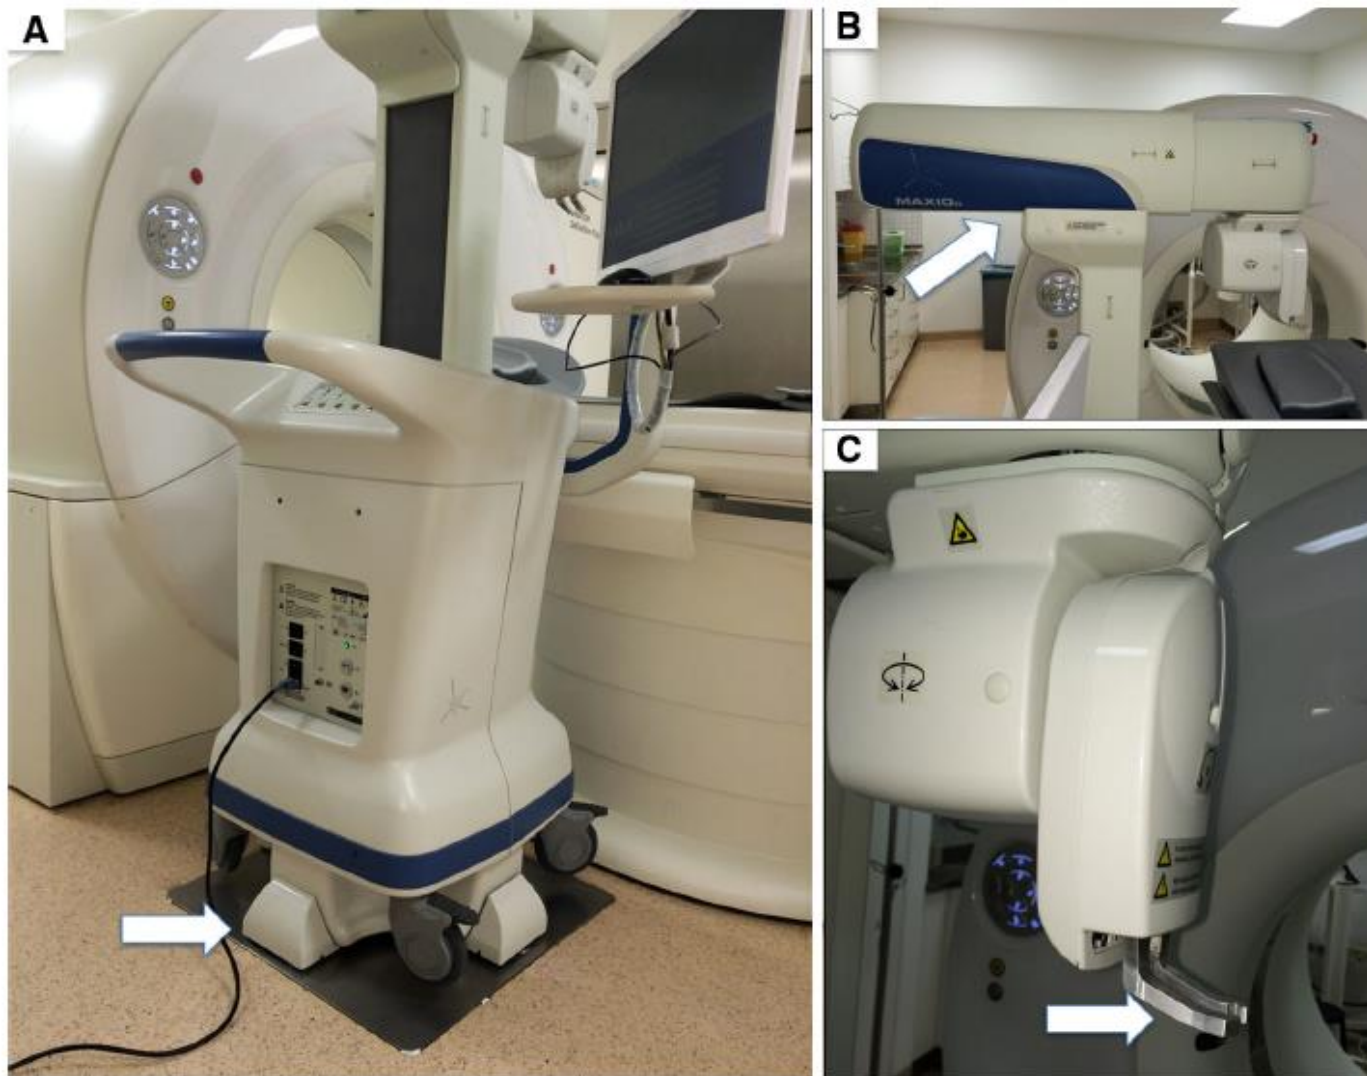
Setup of the robotic assistance device: A Device attached next to CT table on registration plate (arrow). B Robotic arm of the navigation system (arrow). C Needle holder of the robotic arm (arrow) (Size 1710 × 1346)
